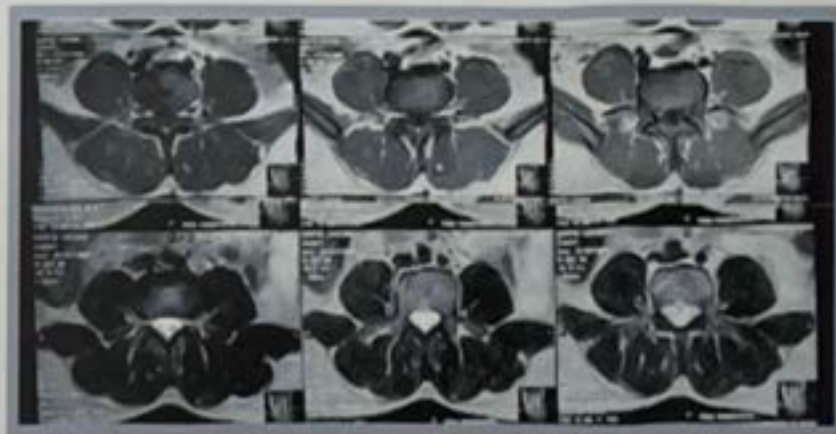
Preoperative axial MRI of the Lumbosacral spine (T1WI, T2WI)
